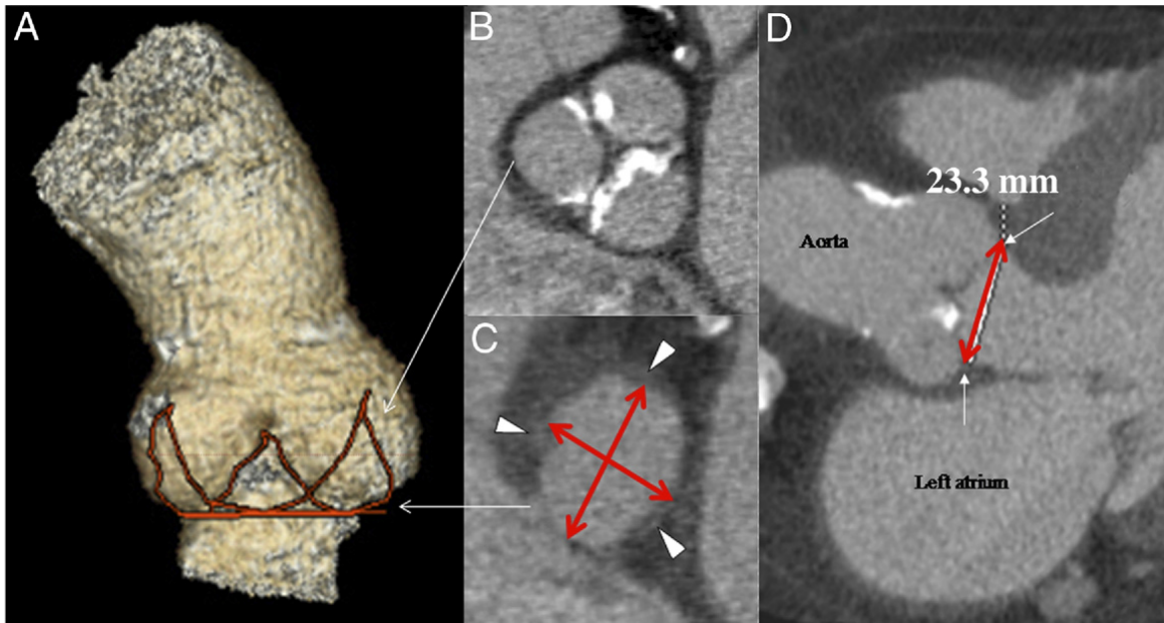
a) 3-dimensional reconstruction of the aortic root b) Ascending aorta at the sinuses level (short-axis view) c) Aortic root at the level of the basal attachment of the aortic leaflet (short-axis view). The red arrows represent the long- and short-axis annular diameters. The white arrows are the hinge points of the leaflets d) Measurements of the aortic annulus in the 3-chamber view (plane similar to echocardiographic long-axis plane) taken from the hinge point of one leaflet to another [48].
